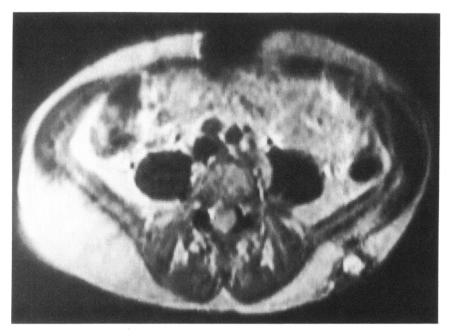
MRI (SE TR=2000, TE=60) demonstrates an area of bright signal due to tumor which is clearly distinguishable from the darker area of scar.
